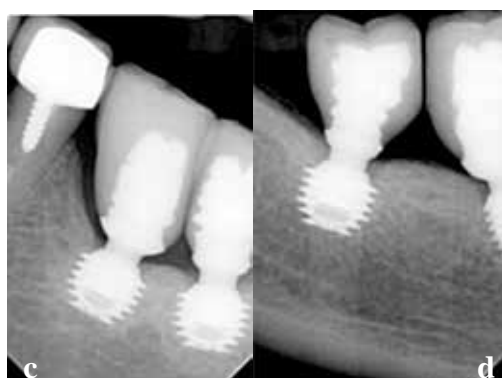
Periapical radiographs after 2 years
